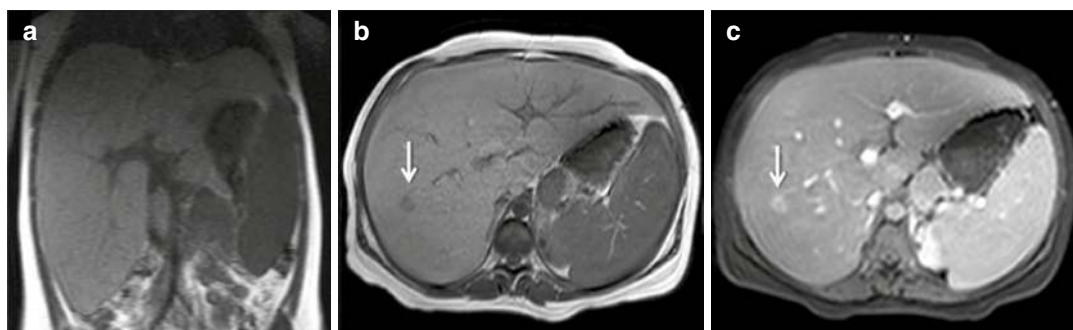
(a) Coronal T1W MRI demonstrating massive hepatomegaly in a 16-year-old girl with type IB GSD. (b and c) Pre- and post-contrast T1W images demonstrating
